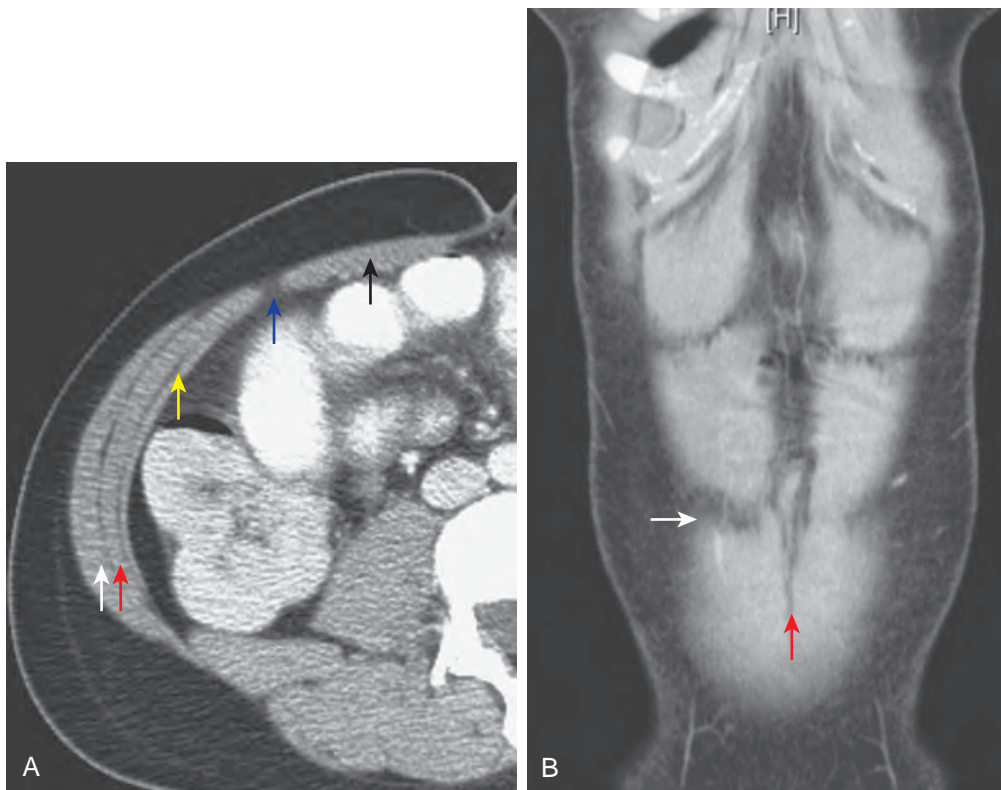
Anterior abdominal wall anatomy. A. Axial CT image of the normal anatomy of the abdominal wall: external oblique muscle (white arrow), internal oblique muscle (red arrow), transversus abdominis muscle (yellow arrow), linea semilunaris muscle (blue arrow), and rectus abdominis muscle (black arrow). B. Coronal CT image of the normal anatomy of the abdominal wall: aponeurosis (white arrow) and linea alba (red arrow).
